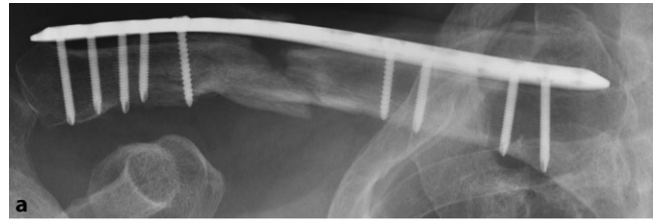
▲ Postoperative x-rays show correct alignment of the fracture in two planes (a, b). A balanced osteosynthesis with sufficient plate length and correct fixation on each side was performed
